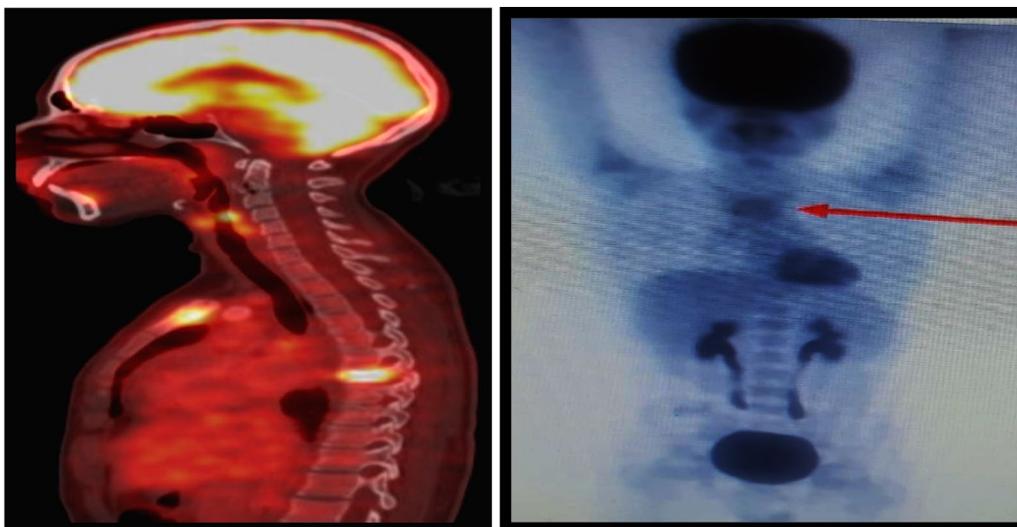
PET-CT study for a 15-year-old male child complaining rapidly growing anterior chest wall mass that was pathologically proved to be HL, nodular sclerosis type. To the left: Initial study shows metabolically active FDG-avid osseous infiltrates at manubrium sterni and DV7. To the right: Interim PET-CT study shows complete disappearance of DV7 lesion with a still residual lesion at sternum with SUVmax ~ 2.2. The interpretation of this study using DS showing a positive result score 4 as sternal activity is higher than that of liver, while rDS = 1.22 which is less than the cutoff point (liver max 1.8). The patient was free till the last follow-up (36 months)
